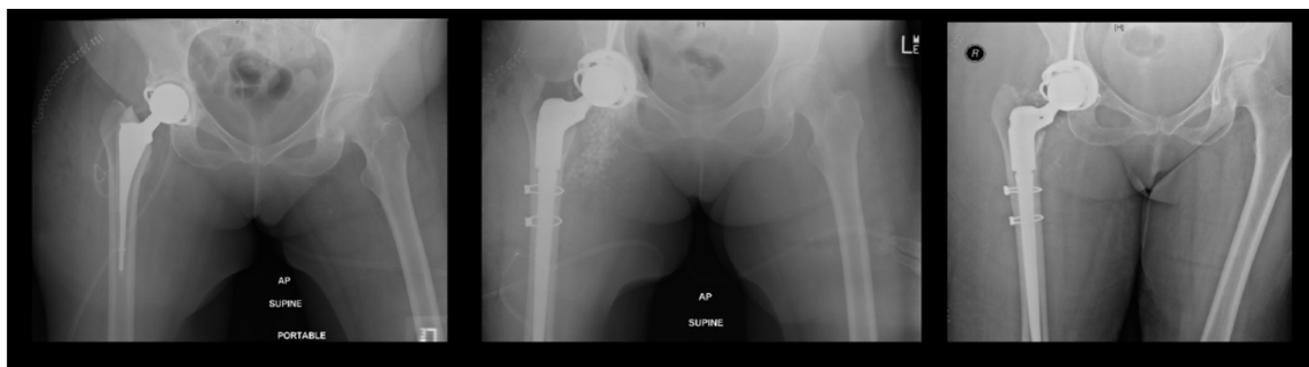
Series of Anteroposterior Supine X-rays, from left to right, initial film May 2014, immediately post-operatively (Aug 18th) and post-operative day 5.
